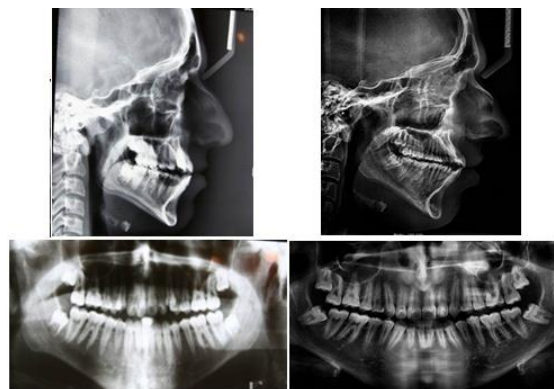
Pre and Post treatment radiographs of case 1(A-Z)
